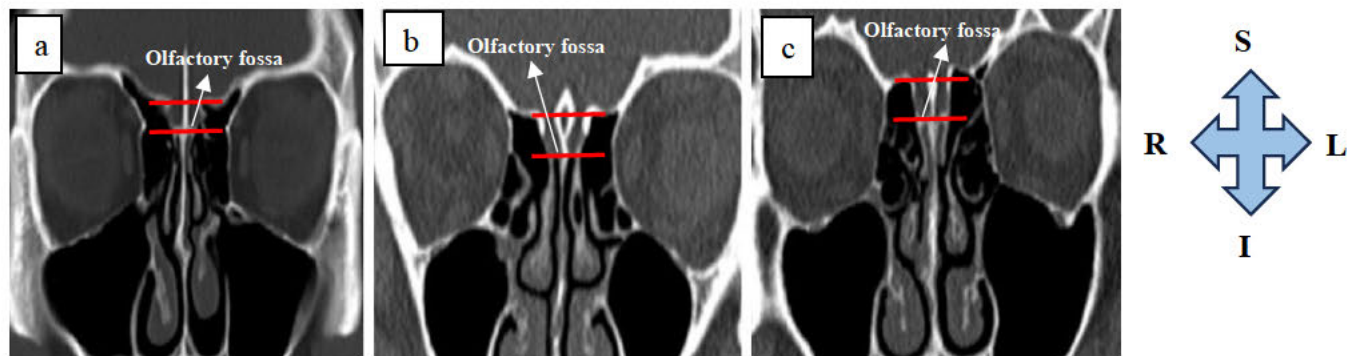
According to the Keros classification, CT images of three types of olfactory fossa in the coronal plane showing Keros classification in coronal view (a) Keros type I (b) Keros type II (c) Keros type III, respectively. Adapted from (Karatay and Avci, 2021).
